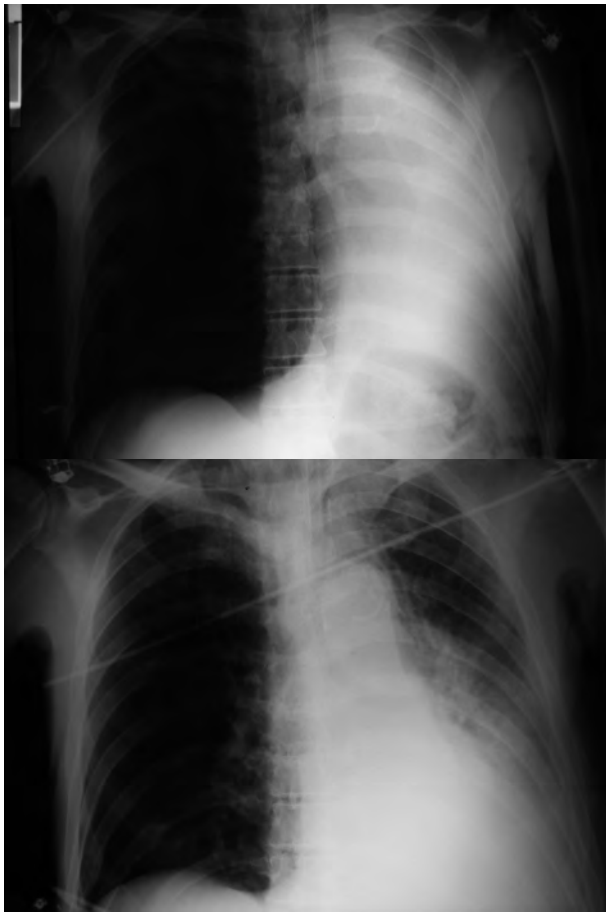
Admission chest X-ray (above) showing right lung atelectasia, and (below) X-ray after bronchoscopy showing subsequent evolution.
